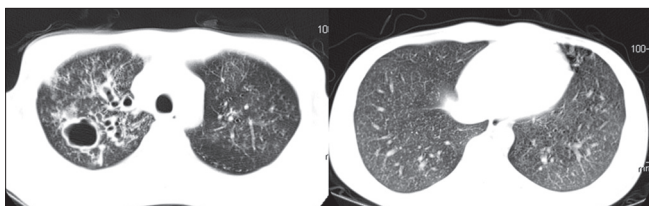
High-resolution computed tomography of the chest at diagnosis showing a large right upper lobe cavity (right) and extensive random nodules in bilateral lower lobes (right)
